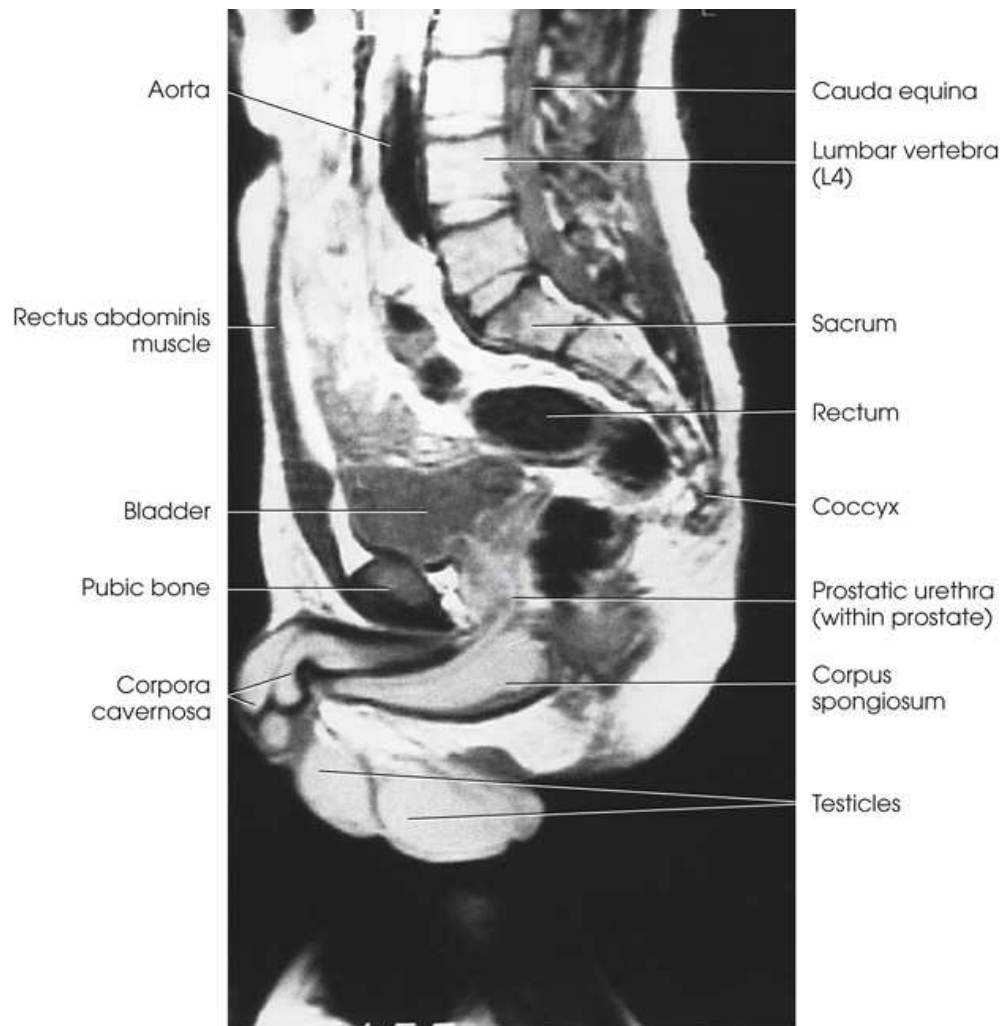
MRI of male abdominopelvic region at midsagittal plane.
